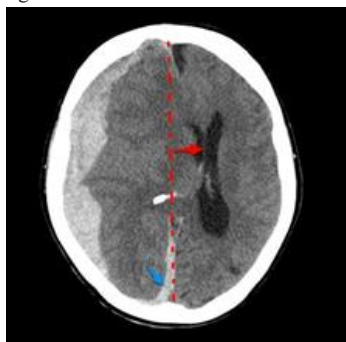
A: CT scan image before craniectomy (midline shift of 1.5 cm to right side)
